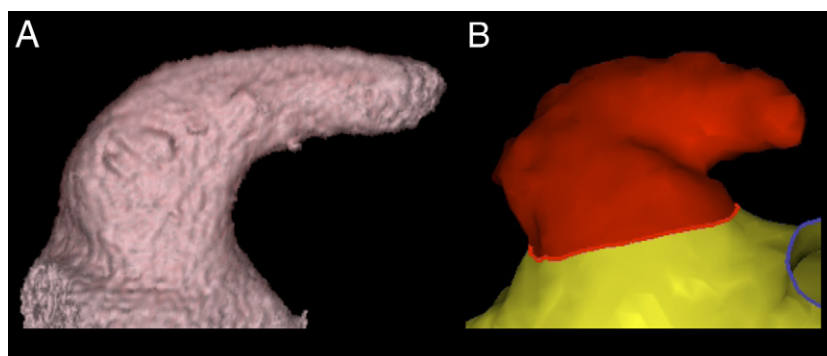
CT and MRI Scans of a Chicken Wing LAA Morphology
